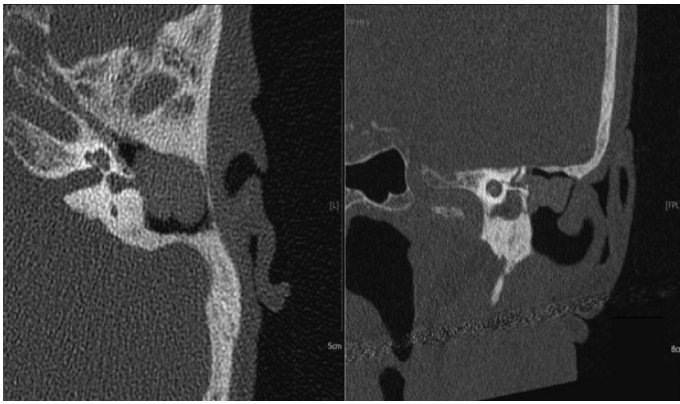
Computed tomography (CT) scan. Lateral semicircular canal dehiscence due to chronic otitis media. The cortical bone of the middle fossa and the tegmen tympani are thinner than expected as a result of the erosive phenomena induced by the reactive tissue.
